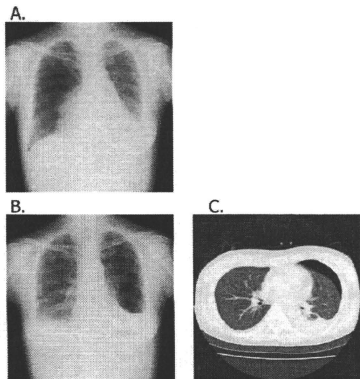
A) Chest X-ray film shows pneumothorax on the right side on February 22nd, 2006. B) Chest X-ray film shows pneumothorax with pleural effusion on the left side on February 24th, 2006. C) Chest computed tomography. There is pneumothorax with pleural effusion on the left lung on February 24th, 2006.
